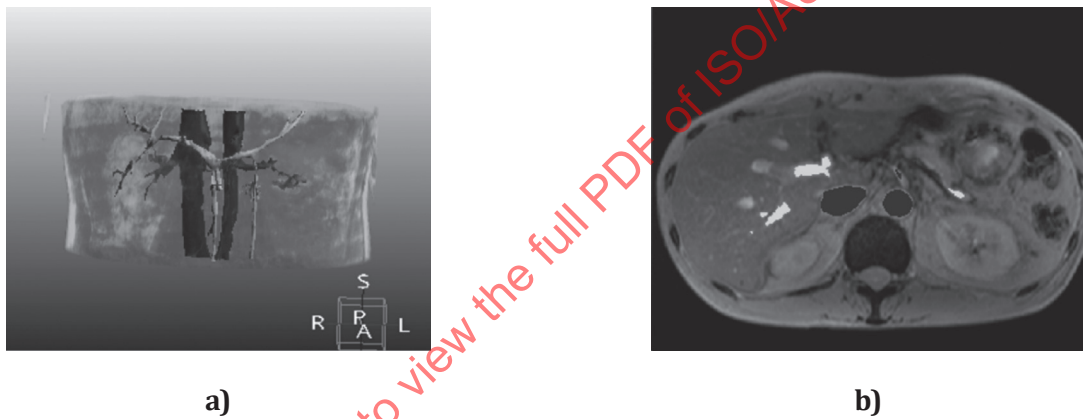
Soft tissue segmentation a) 3D visualization b) segmented vessel region of MR image
